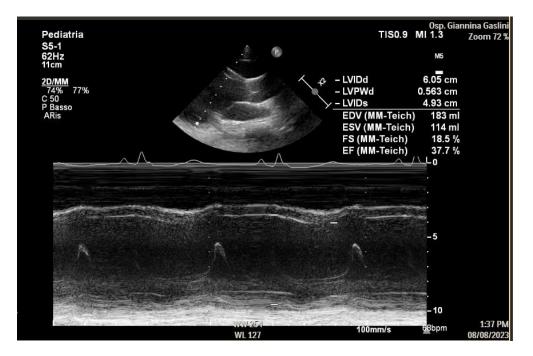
Echocardiographic image of a 23-year-old patient in our cohort, conducted at our Institute, that shows left ventricle dilated, globular, thinning walls, global hypokinesia, resulting in a severe reduction of global systolic function.
